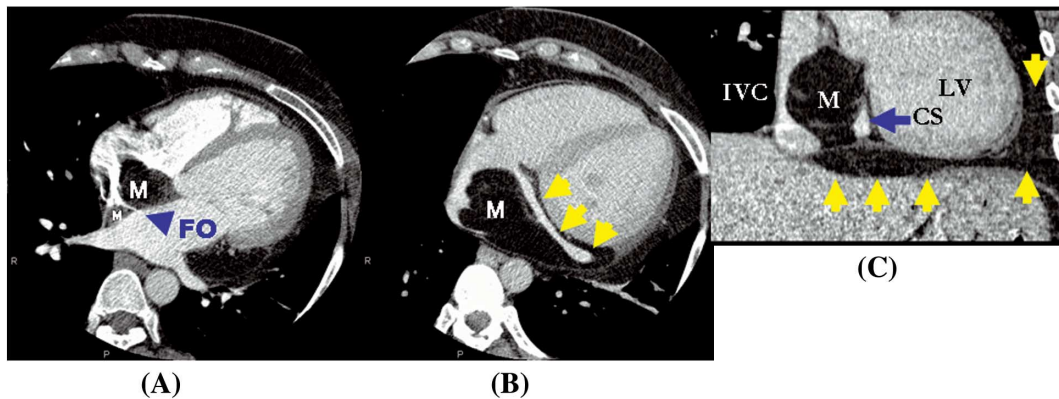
(A) Multislice computed tomography image show typical waist in the fatty mass at the level of the fossa ovalis, producing a dumbbell shape and wedge-shaped lateral part. (B) Lipomatous hypertrophy of the interatrial septum with a “finger-like” projection of fat along the coronary sinus (arrow). (C) Coronal image shows encasement and mild compression of the inferior vena cava. The coronary sinus is surrounded by the fat. Also note the increased pericardial fat (yellow arrowheads). M, fatty mass; FO, fossa ovalis; IVC, inferior vena cava; CS, coronary sinus; LV, left ventricle.
